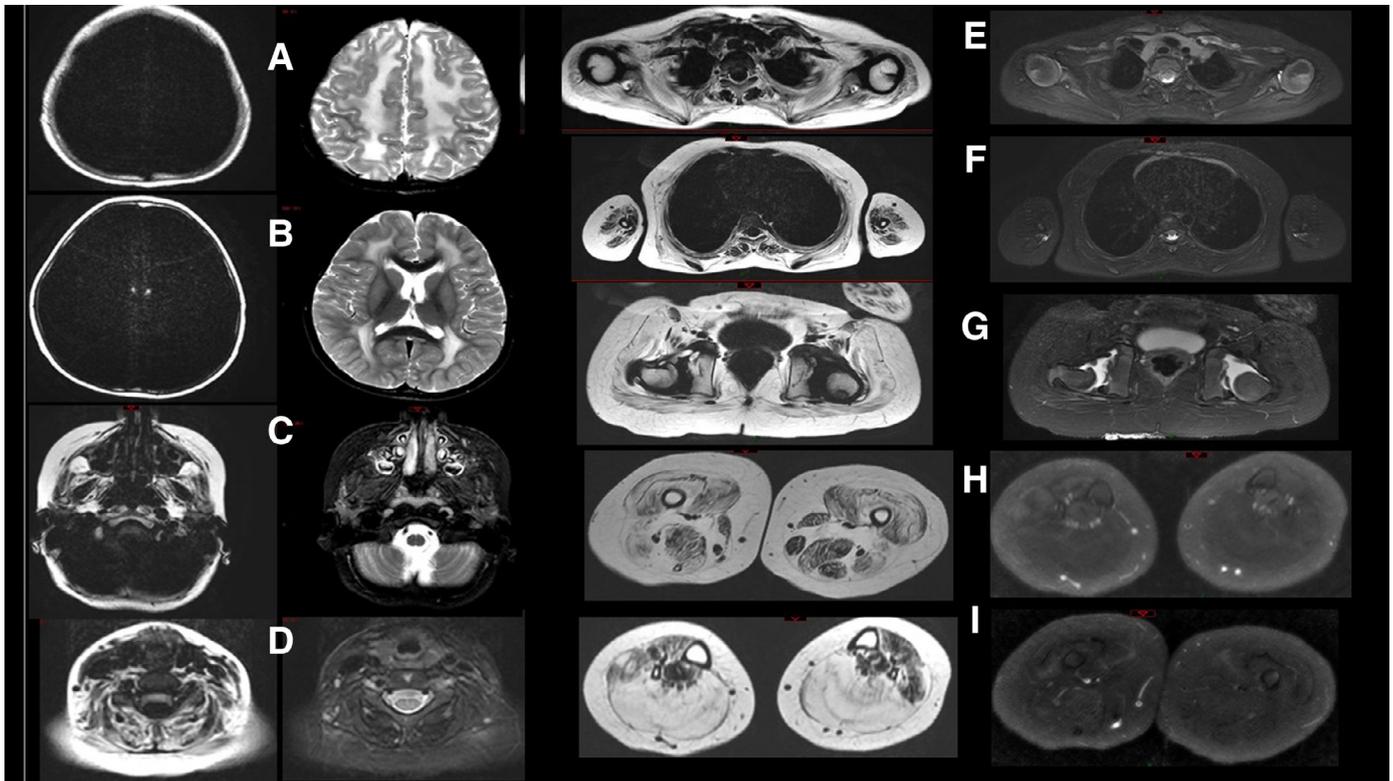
demonstrating importance of “whole body” MRI, with axial IDEAL T2 sequence from head to toes in seven year old boy from North Africa with a presentation of congenital inherited muscular disorder associated with elbow, hip and knee severe deformities and retractions. The fat images are presented on the left and water images on the right at each level of the selection of nine of the 206 obtained images.
